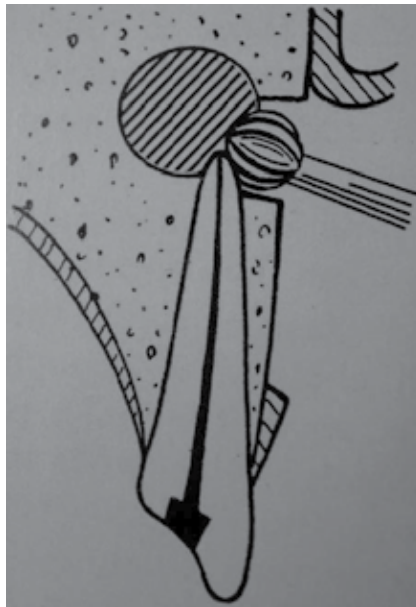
Periapical exposure
